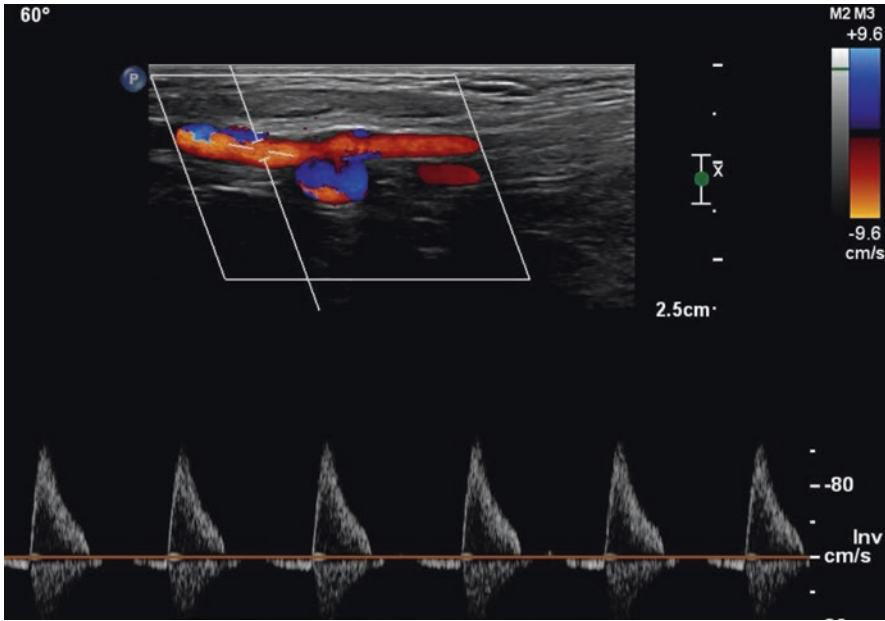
Pulsed wave doppler of the femoral artery displays the classic pulsatile arterial tracing
